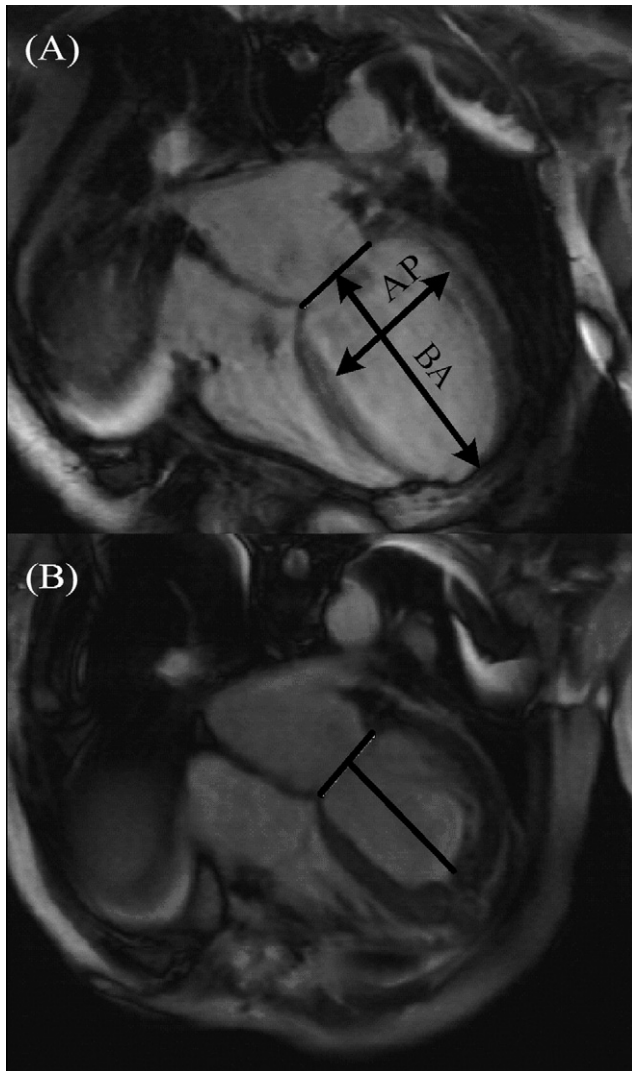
Long-axis MR images of a patient before (A) and after (B) SVR. Multiple short-axis cine images from the apex to the base of the heart (or orientated axial) and long-axis cine images are used to quantify LV function. Anterior to posterior (AP) and base to apex (BA) were measured from 2-dimensional MRI before and after SVR during the cardiac cycle. The SI was calculated as AP/BA.
